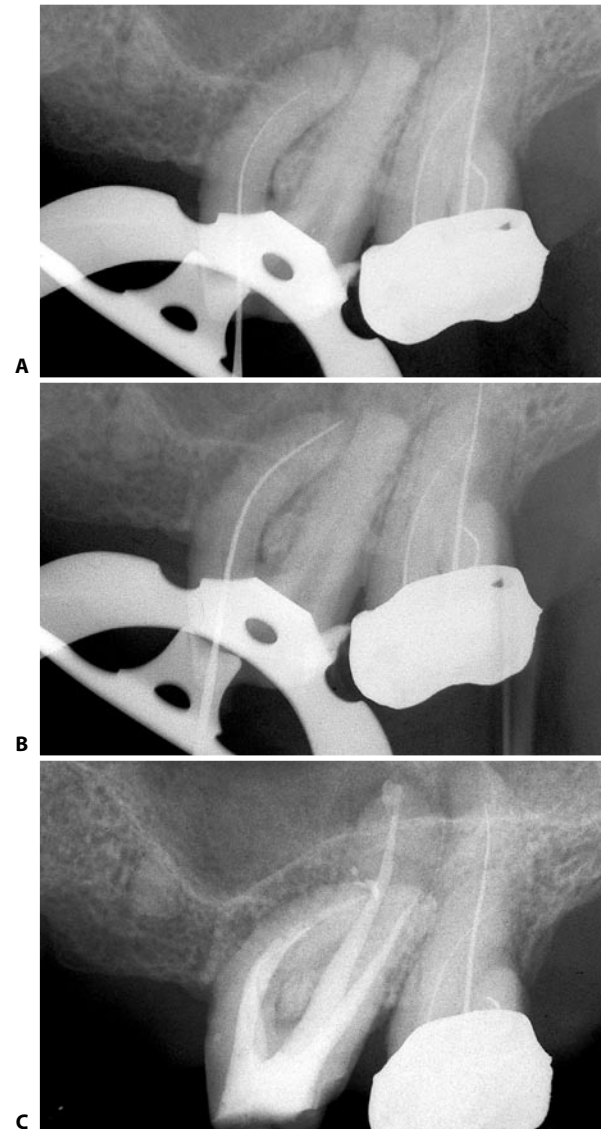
An upper left first molar with a curvature in the coronal third of the mesiobuccal root. A. Intraoperative radiograph. The instrument is unable to advance to the radiographic terminus of the canal because of large interferences in the curve of the coronal third. Note the distal inclination of the instrument shaft. B. Intraoperative radiograph of the last instrument at the radiographic terminus of the canal. The curve of the coronal third has been eliminated by the first file introduced in the canal and then the various instruments can comfortably reach the apical third. Note the mesial displacement of the instrument shaft. C. Postoperative radiograph.
